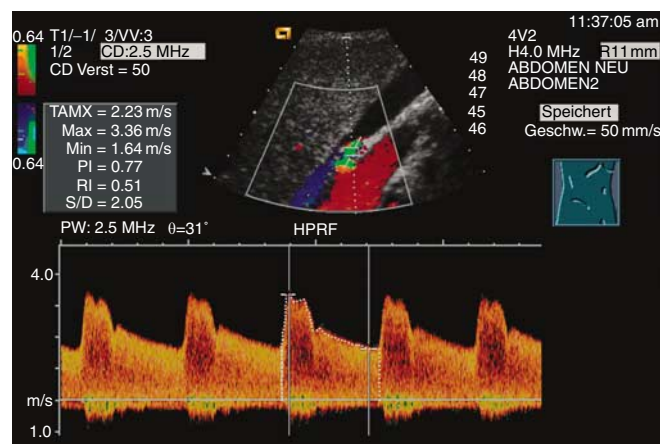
Color duplex sonography of right-sided ostial renal artery stenosis. High peak systolic velocity of 3.36 m/s is obtained within in the stenosis. The green color indicates high blood flow velocity with turbulences near the stenosis. Low mean resistive index (RI = 47) of the right kidney is an indirect sign of significant stenosis.
